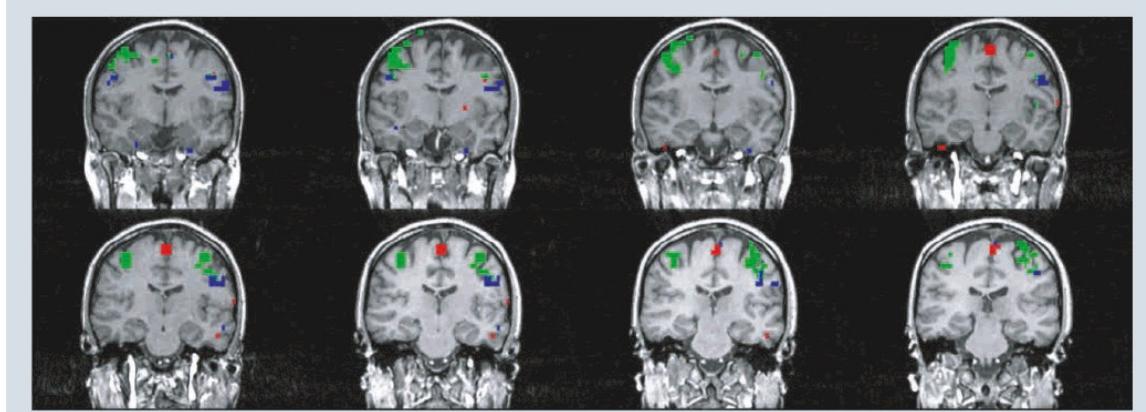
Localization of the different parts of the motor gyrus using functional MRI. The location of the foot homunculus is seen in red, the hand in green and face/tongue in blue, respectively.
